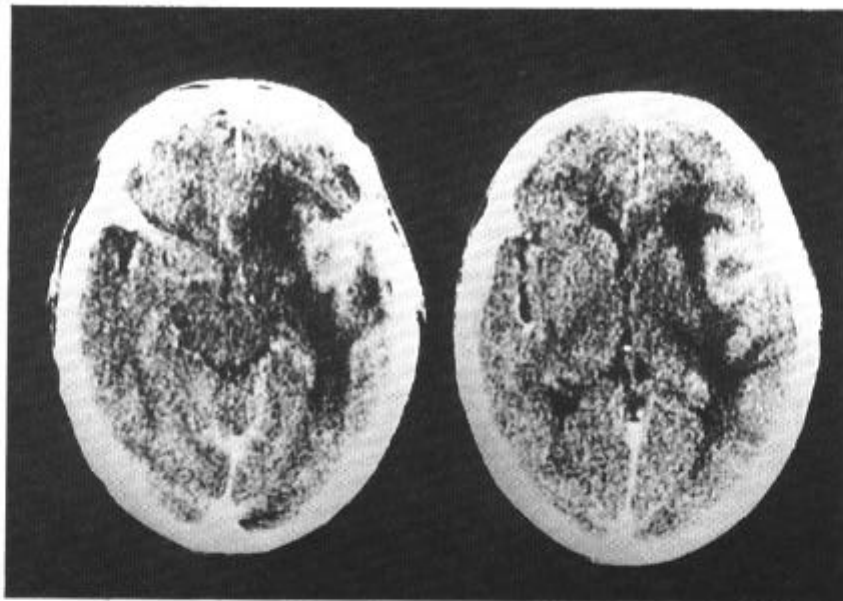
A CT scan of case 3 revealed an enhanced tumor with a surrounding lowdensity area in the right fronto-temporal region .
